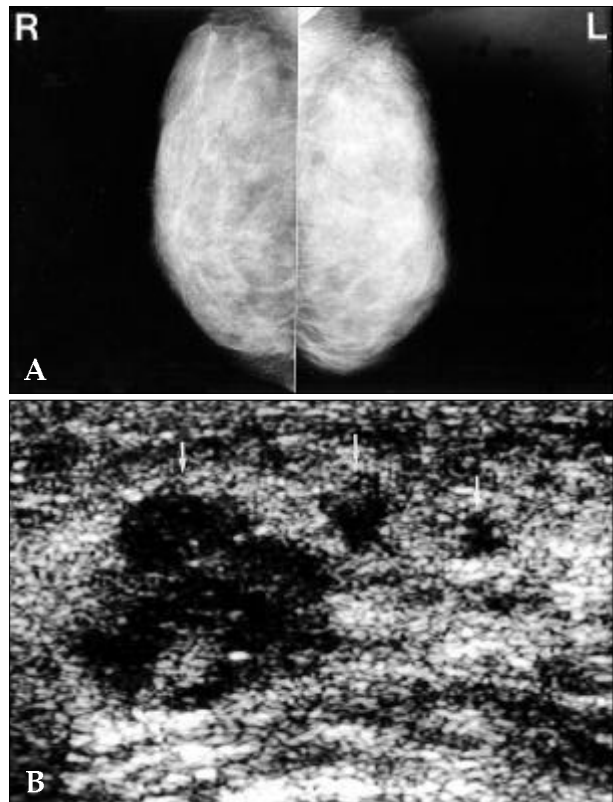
Lymphangitic metastasis to the breast from stomach cancer in a 37-year old woman. (A) Mediolateral oblique mammogram of the left breast shows diffuse increased parenchymal density. (B) Ultrasound of the left breast shows irregular shaped hypoechoic nodules (arrows) with nonhomogeneous texture, ill-defined margin, and diffuse skin thickening.
